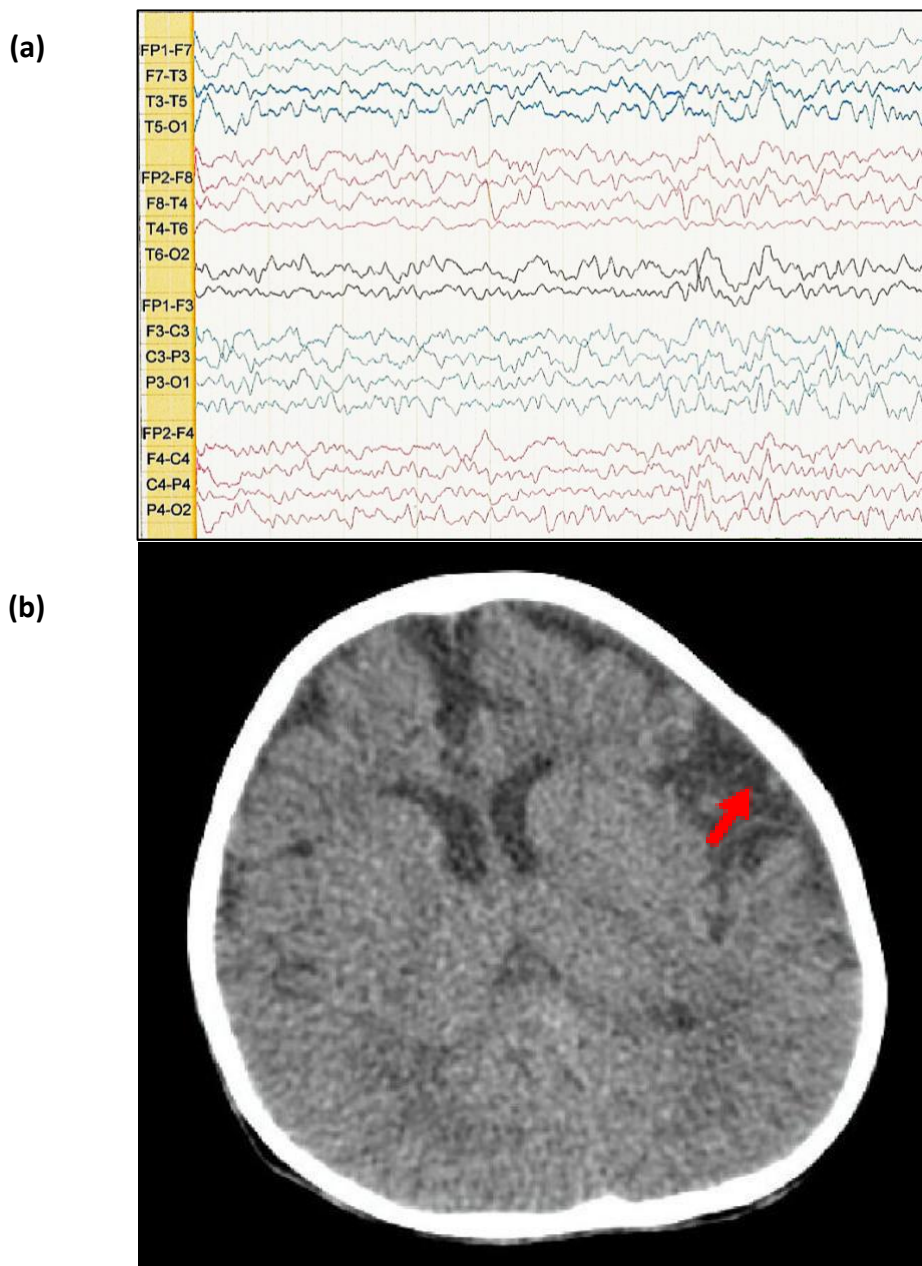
(a) EEG showed abnormal with diffuse slowing; (b) brain CT scan showed cerebral atrophy, microcephaly and left arachnoid cyst on the middle cranial fossa (red arrow).
